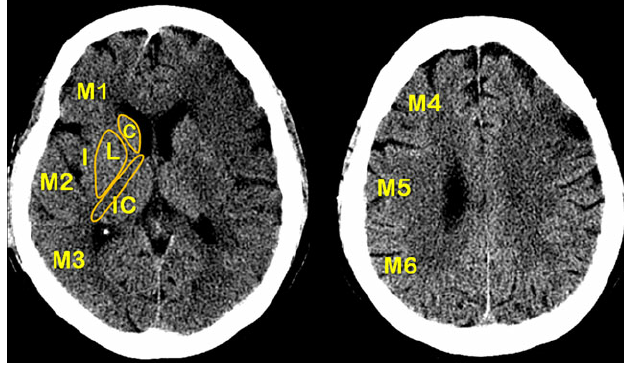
ASPECTS area in CT imaging[5]
